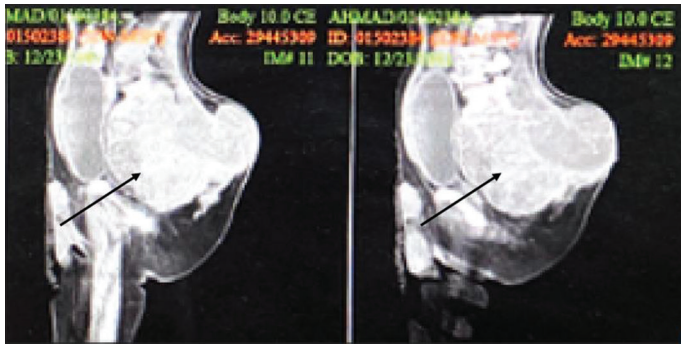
Additional computed tomography scan vertebrae sacral. Black arrow depicting the sacral chordoma
